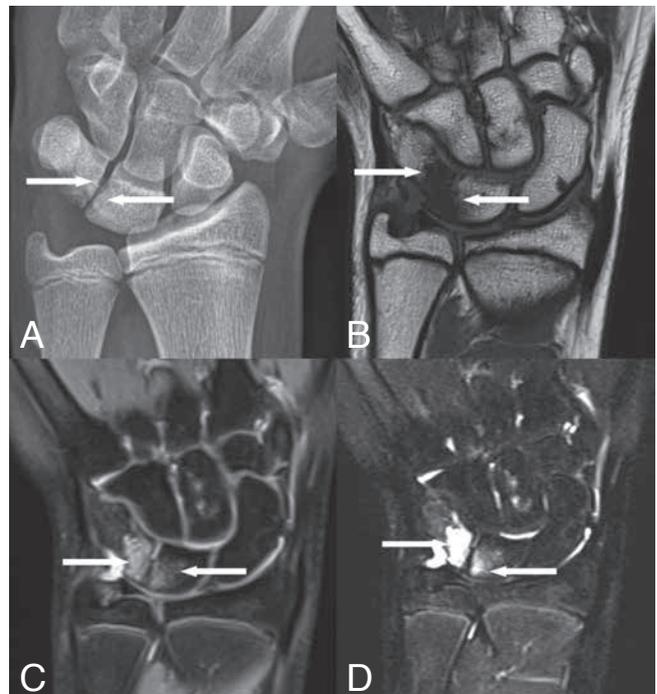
Symptomatic patient with LTC type 1 (patient 3). A: Plain radiography and B: Coronal SE T1-WI, C, SE proton density and D, SE T2-WI. Type 1 LTC with subchondral cysts (A) and surrounding edema (B-D) in a patient with ulnar sided wrist pain.
